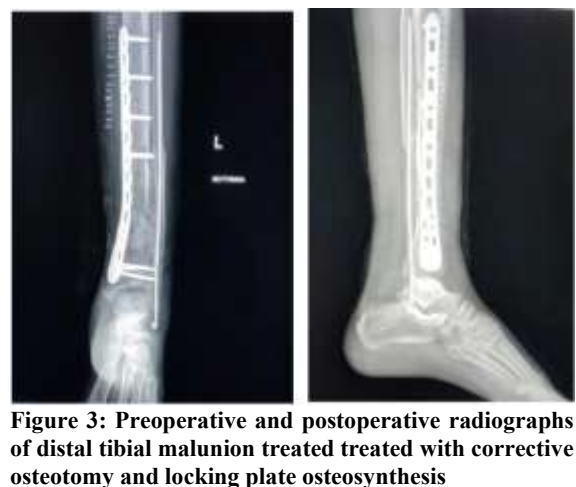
Preoperative and postoperative radiographs of distal tibial malunion treated treated with corrective osteotomy and locking plate osteosynthesis
